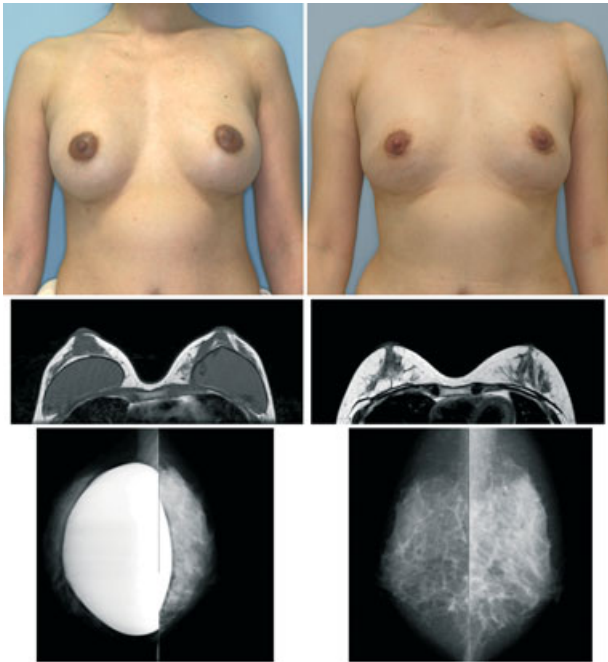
Clinical and radiological views of Case 3. Preoperative (left panel) and postoperative views at 12 months (right panel). Clinical views show capsular contracture resulting in an unnatural round shape of both breasts before surgery (top, left), while the breasts looked natural with a minimal loss of breast volume at 12 months (top, right). The T1-weighted MRI (middle, left, and right) revealed that the fatty layers around the mammary glands were thicker at 12 months when compared with baseline. Mammograms detected small calcifications in the right breast at 12 months (bottom, right), which were present before surgery and were not induced by lipoinjection (bottom, left). Augmented breast mounds were very soft and had natural skin texture with no visible injection scars (see also Video S3).
